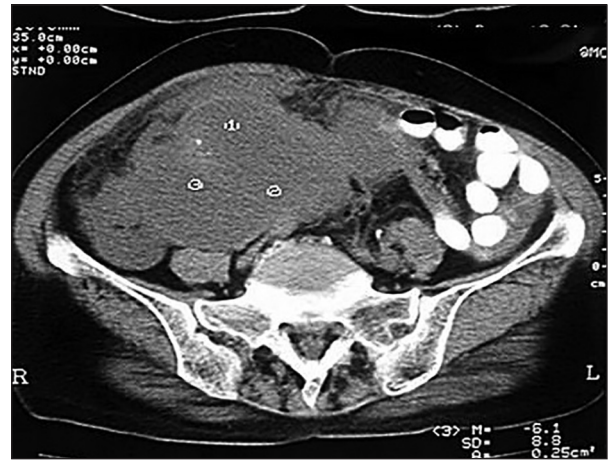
Computed tomography revealed a large cystic mass with irregular margins measuring 8.6 cm × 7.5 cm × 6.2 cm in the right lower abdominal cavity
